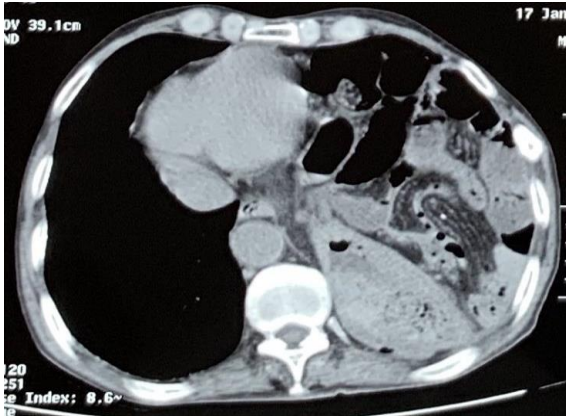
TAP CT showing the presence of the small intestine and the intrathoracic stomach (CHU Hassan II)
